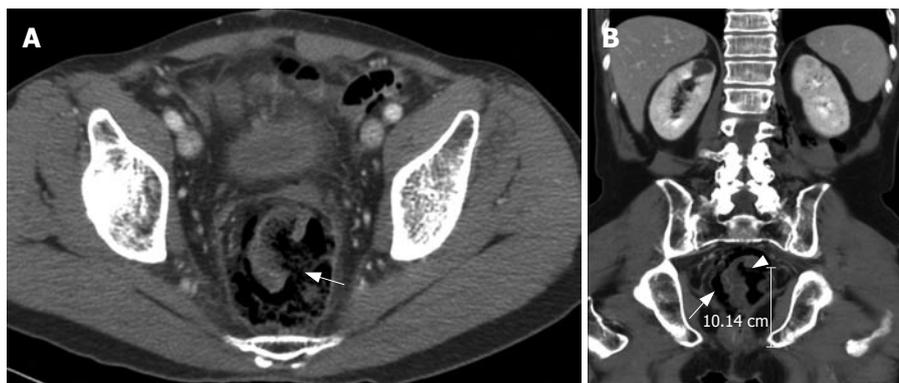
Abdomino-pelvic CT at the level of acetabula showing air bubbles mixed with small solid particles surrounding both lateral aspects of the rectum (arrow) (A) and coronal view of extraluminal air in the pelvic cavity (arrow) and rupture of the left lateral wall of the rectum (arrow head) (B).
